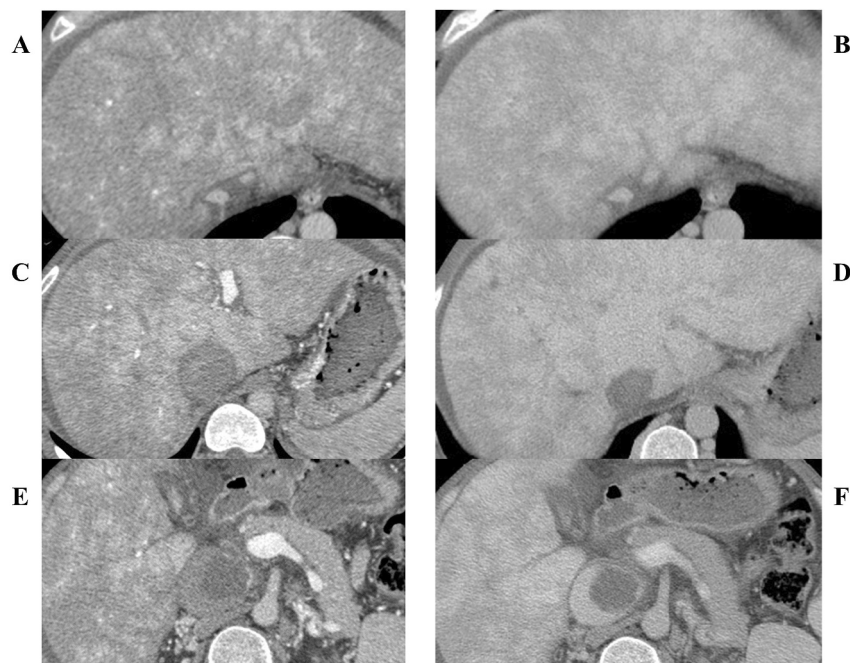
Abdominal contrast-enhanced computed tomography image. (A) Hepatic head lateral division portal phase. (B) Hepatic head lateral division equilibrium phase. (C) Hepatic hilum portal phase. (D) Hepatic hilum equilibrium phase. (E) Hepatic caudal division portal phase. (F) Hepatic caudal equilibrium phase. Partial thrombo-occlusion of the inferior vena cava is observed at the hepatic level. (A, B) The three main trunks and branches of the hepatic veins are occluded and are not contrasted. (C, D) In porta hepatis level slices, thrombo-occlusion is more advanced, and most of the lumen of the inferior vena cava is thrombosed. (E, F) Furthermore, the inferior vena cava is markedly dilated caudally, with 60% of its lumen thrombosed. The intrahepatic space is coarse and cirrhotic, and ascites is observed on the hepatic surface.
